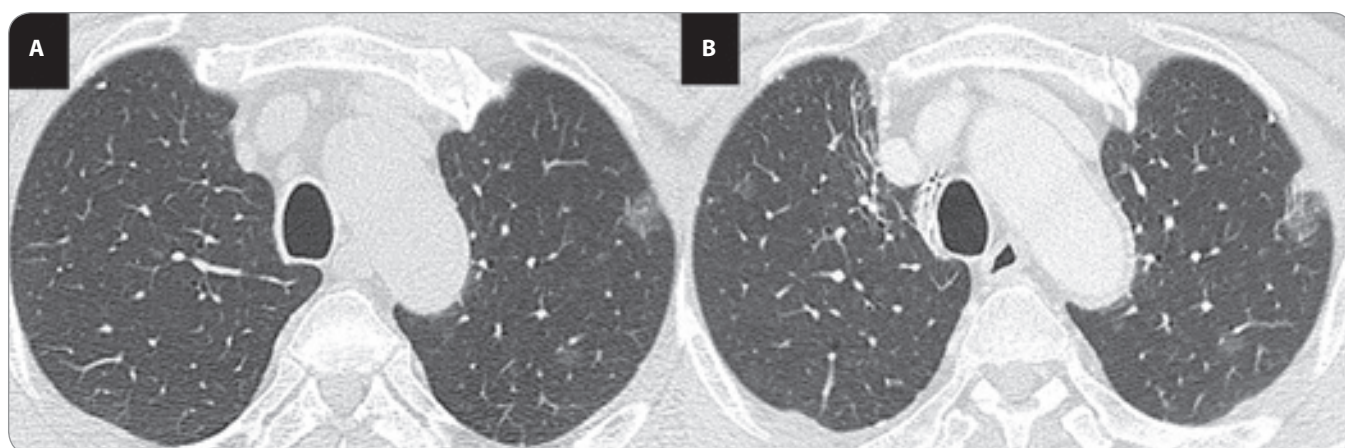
A ground-glass opacity (GGO) nodule in the left upper lobe that was present at the initial consultation (A) had grown in size on a CT scan performed 1 year and 4 months after the right lung resection (B).
